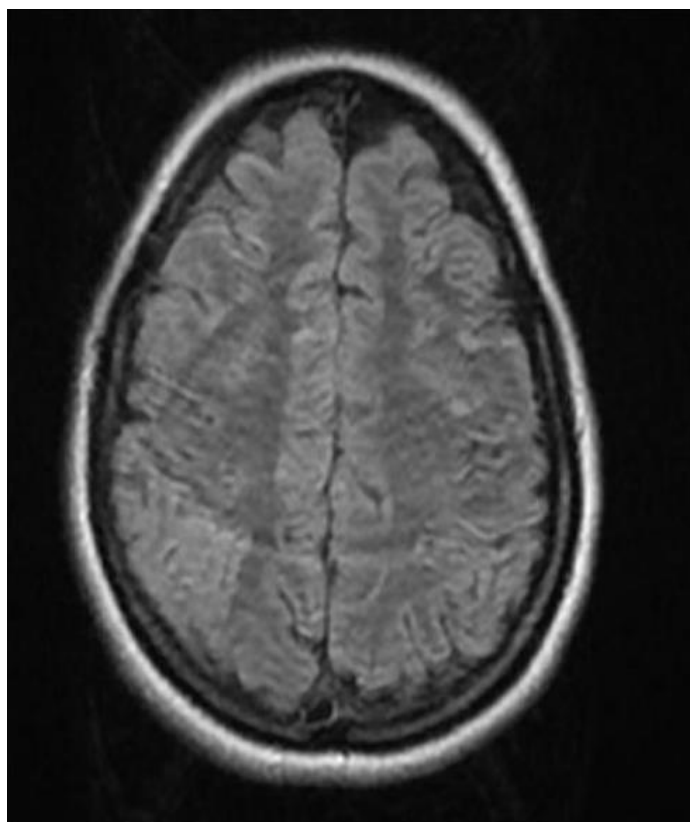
First MRI of the brain
